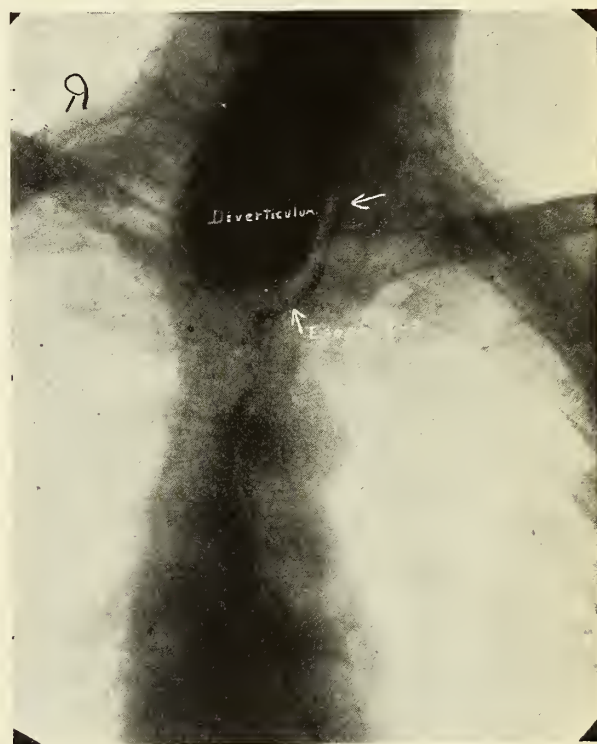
X-ray picture showing barium-filled esophageal diverticulum, right side.
